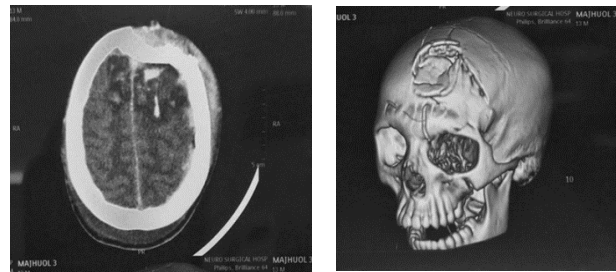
A: non-contrast CT scan shows an axial section of the brain and bone window Showing depressed left frontal skull fracture with underlying multiple bilateral brain contusion and interhemispheric hemorrhage, B: 3D reconstruction brain CT scan showing partial depressed fracture of the frontal bone midline and Paramedian to the left with multiple Comminution reveals the presence of significant depressed skull fracture.
